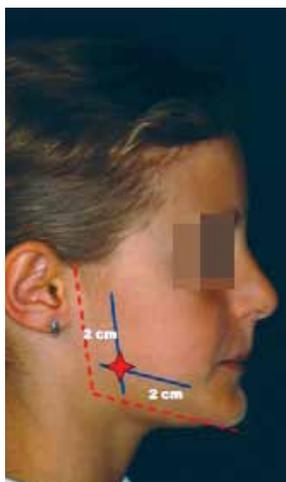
Lines drawn on the skin of the patient to perform ultrasonography. The US measurement site was better identified by tracing two straight lines on the skin of the patient. The first was drawn parallel to and 2 cm distant from the mandibular base; the registration was performed at a point on this line keeping the probe 2 cm from the posterior edge of the mandibular ramus, where the second line was drawn.
